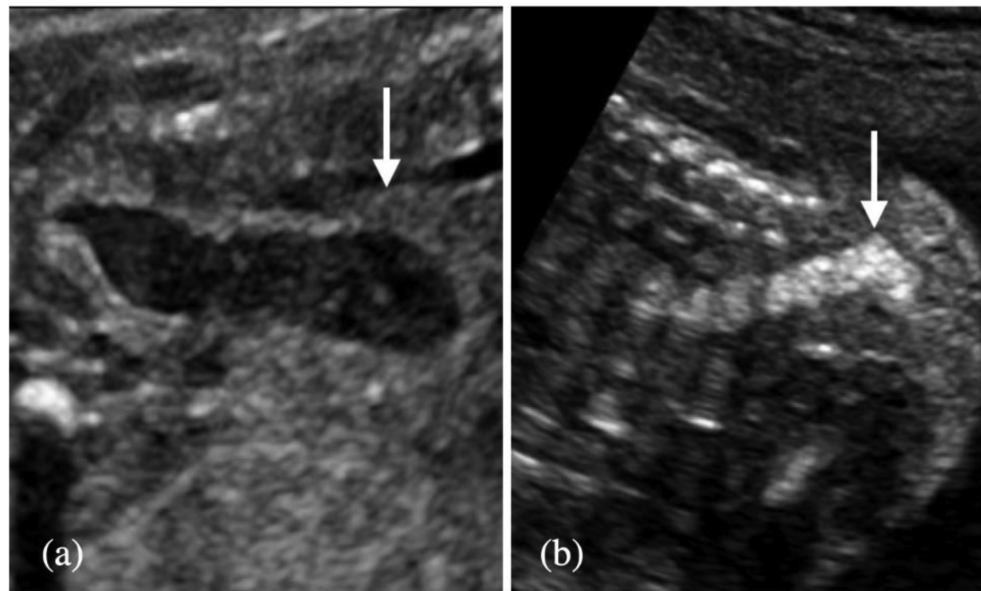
Appearance of indirect findings of anorectal malformations on 2D ultrasound.
